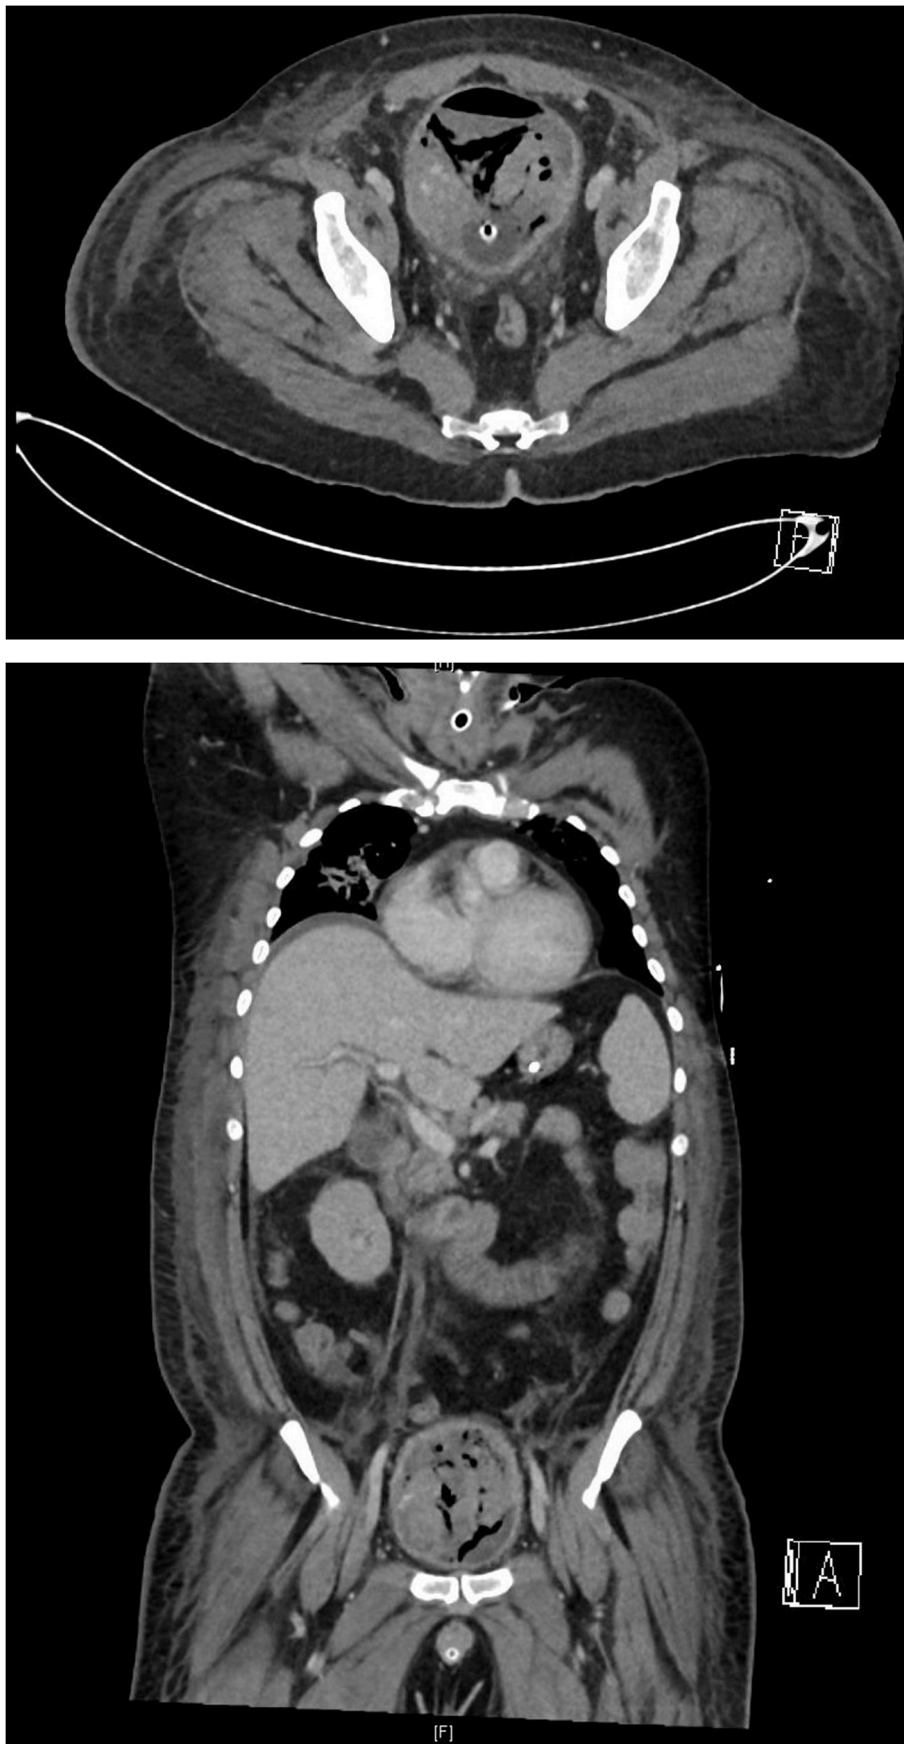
CT scan conducted 2 days prior to third cystoscopy, showing large volume intravesical blood clots, with features of cystitis. (a) Axial view (b) Coronal view.
